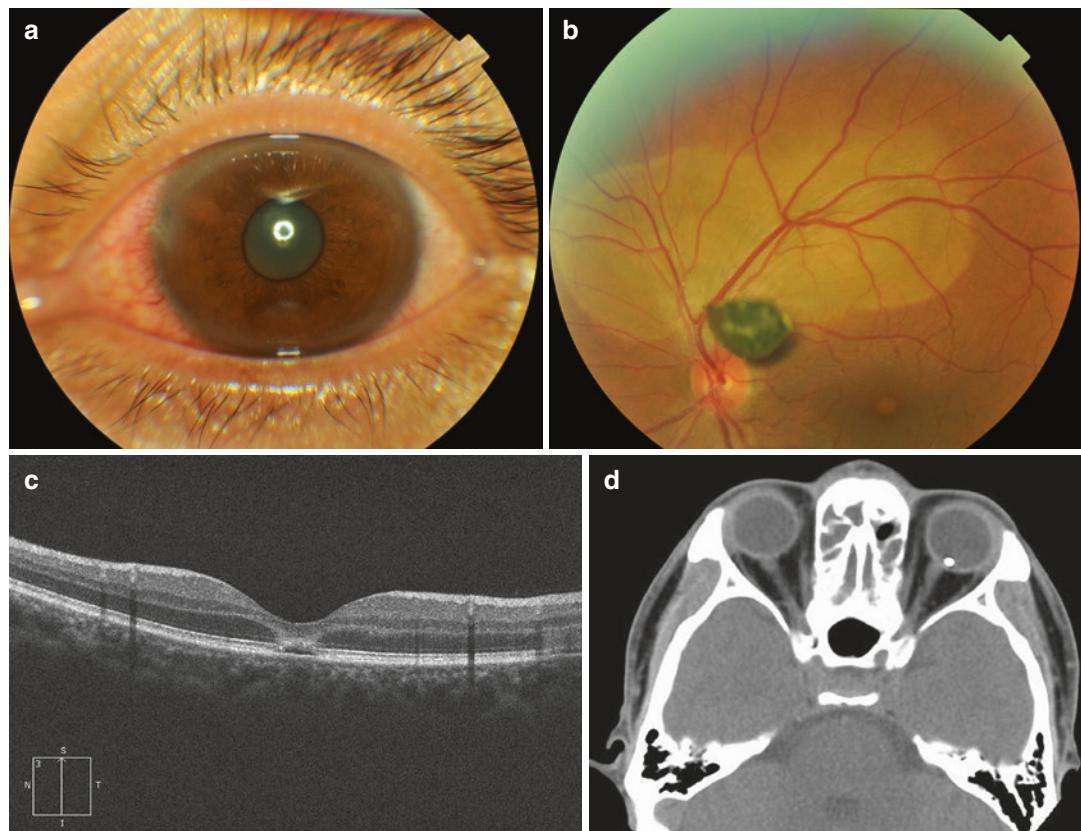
(a) Anterior segment photo, (b) fundus photography, (c) OCT and (d) CT scan of a patient with epiretinal foreign body
